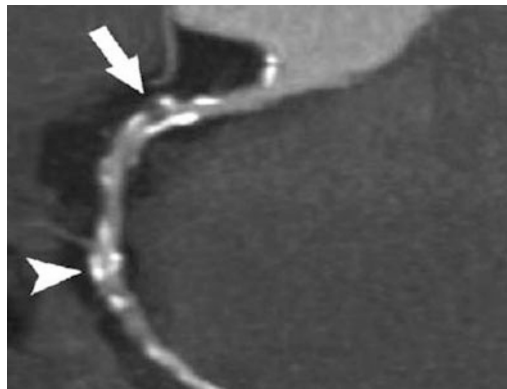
Coronary vascular narrowing demonstrated by computed tomography (Source: http://en.wikipedia.org/wiki/Computed_tomography_of_the_heart)
